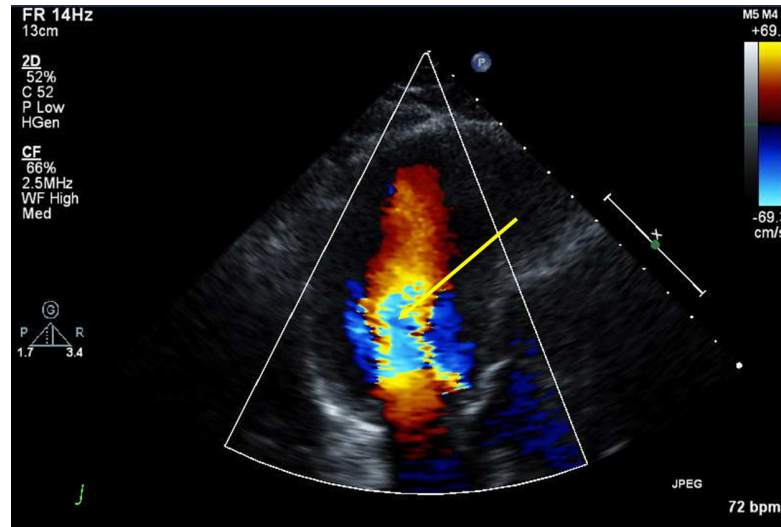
Aliasing of color doppler imaging. Color image displays regions of aliased flow (yellow arrows).
